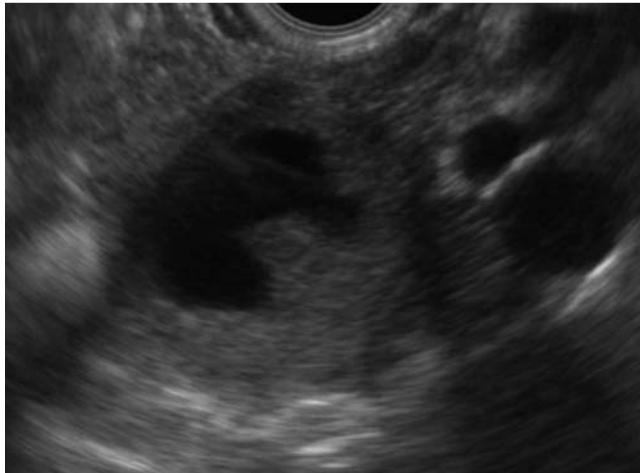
Endoscopic ultrasound (EUS) image demonstrating the pancreatic lesion, which appeared oval with a thin and hypoechoic rim and a central, anechoic part; the lesion was 22 × 18 mm.
